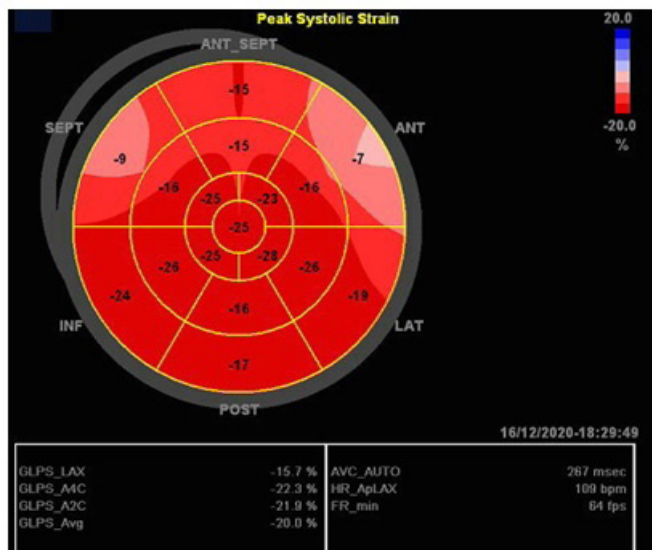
Strain echocardiography image supporting cardiac amyloidosis in the inferolateral wall, evident in the anterolateral and septal wall, with the apex area preserved.
